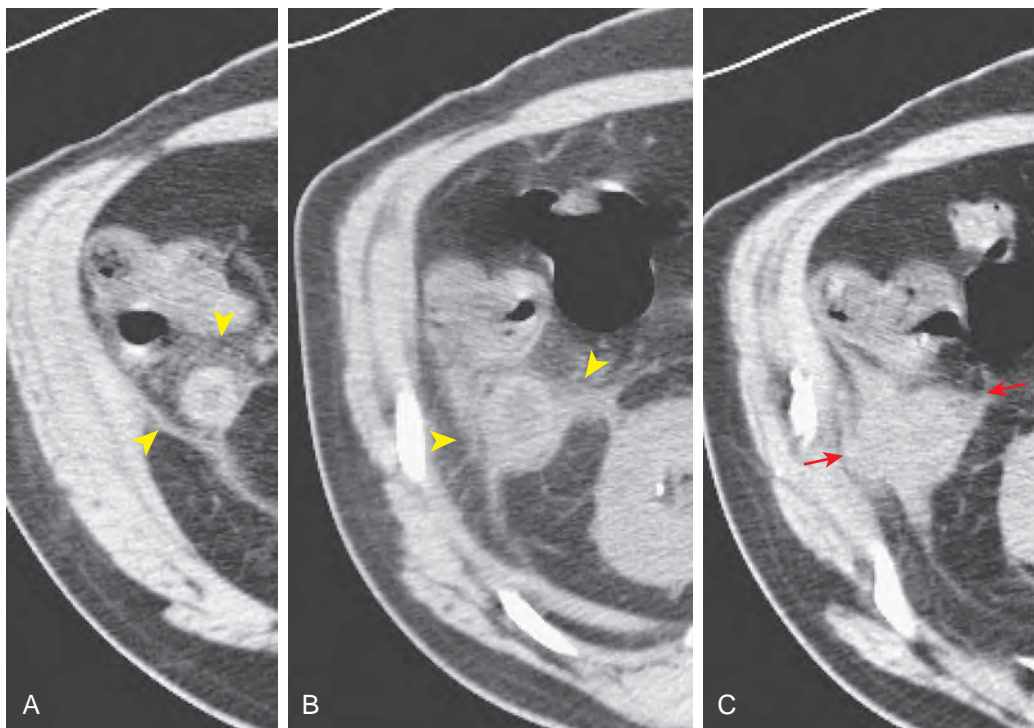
CT scans of carcinoma of the distal appendix. A-C. Series axial CT scans of the right, mid, and lower abdomen show that a lobulated soft tissue mass (arrows) is present in the distal aspect of the appendix, with mural thickening identified in the more proximal appendix. Periappendiceal inflammatory changes are also identified (arrowheads).
